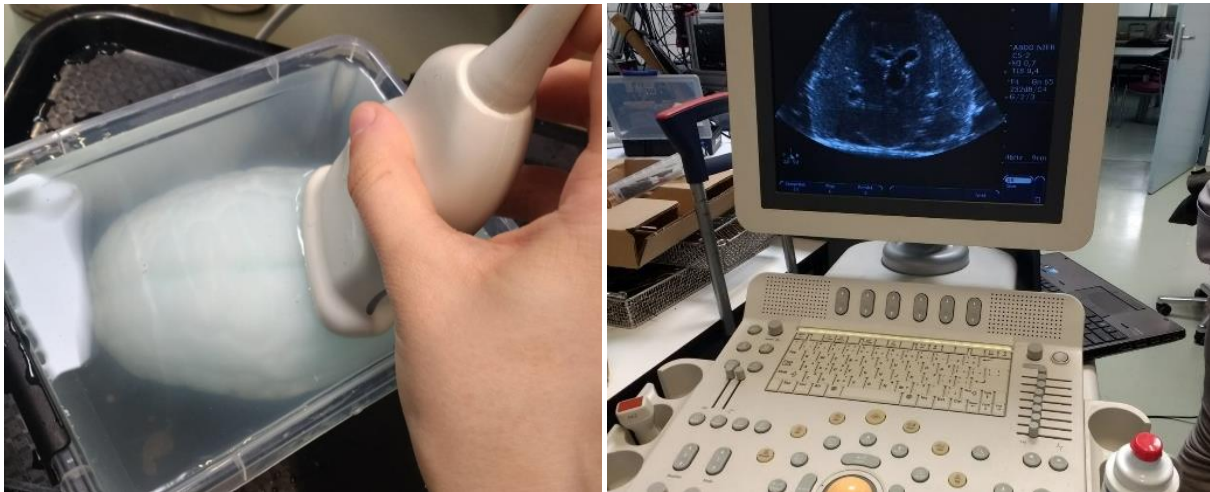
ULTRASOUND IMAGING SET UP
